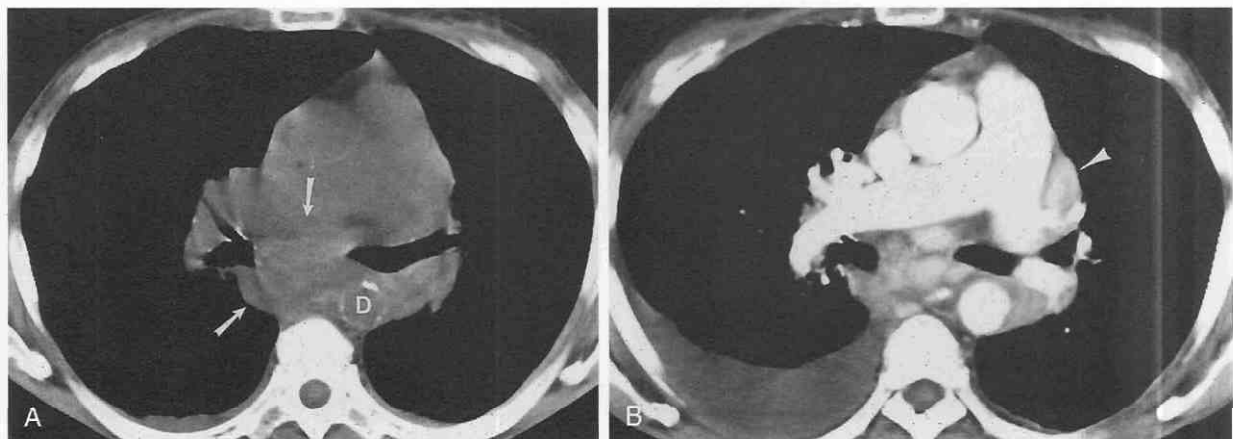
Disseminated Castleman's disease. A, CT shows marked subcarinal adenopathy (arrows). Paratracheal and prevascular adenopathy was extensive (not shown). D, descending aorta. B, Contrast-enhanced CT shows marked enhancement of subcarinal and aortopulmonary window (arrowhead) lymph nodes. A right pleural effusion can be seen.
